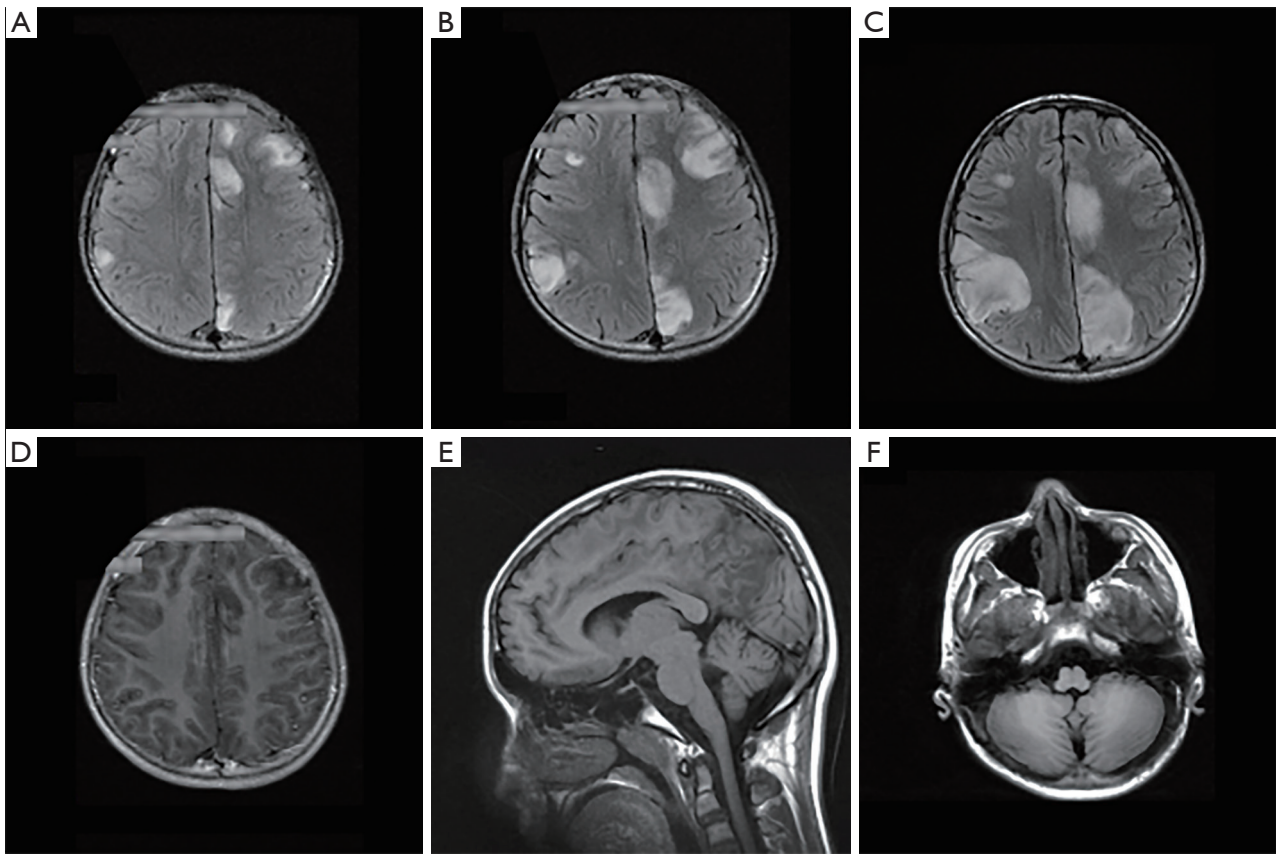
Additional imaging features of the novel R317S variant. (A-C) Sequential MRIs taken 2 weeks apart from each other showed increased size of the cortical signal abnormalities on Axial FLAIR sequence. (D) No abnormal gadolinium enhancement was seen on contrast-enhanced T1-weighted imaging. The sagittal (E) and axial (F) T1-weighted imaging did not reveal clear cerebellar atrophy.
